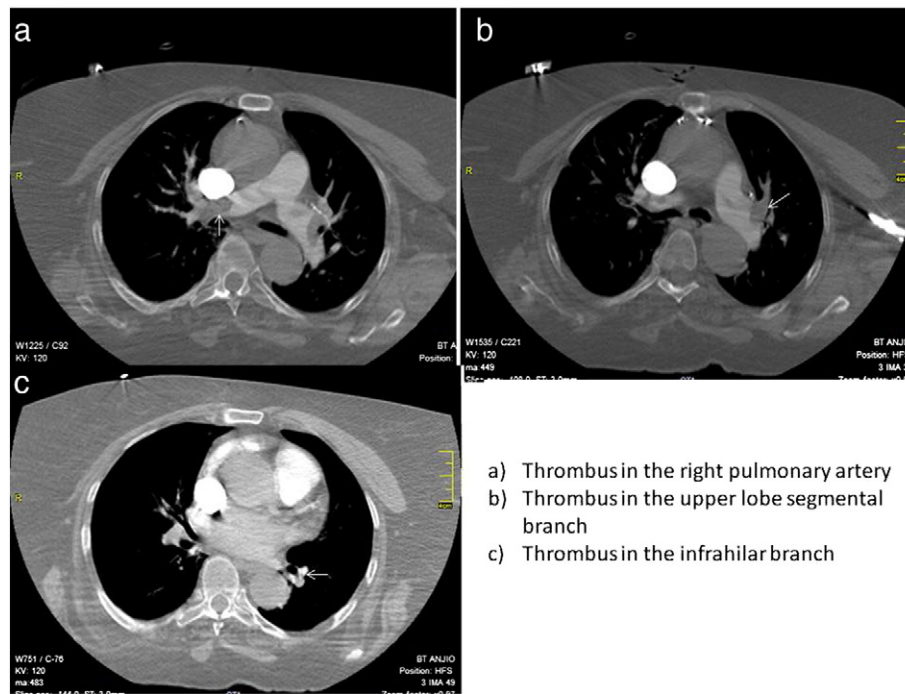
Pulmonary CT-angiography of patient.
